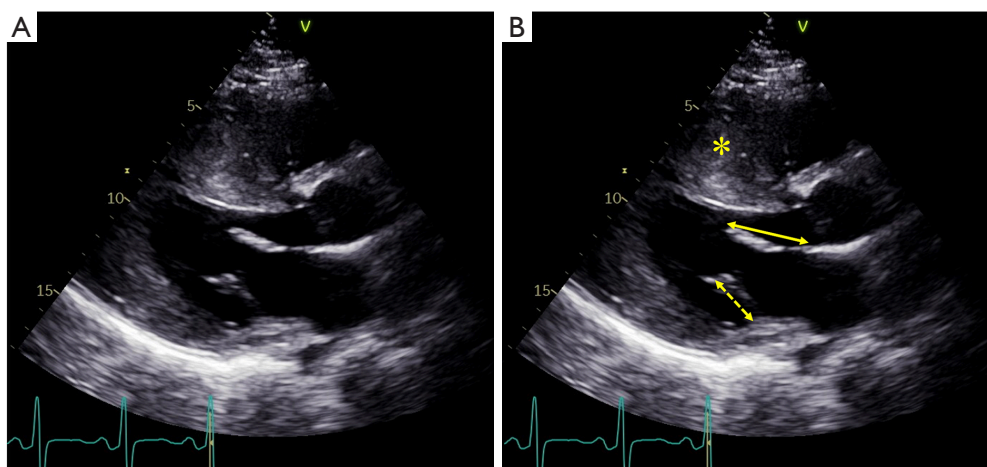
Elongated mitral valve leaflets in hypertrophic cardiomyopathy. (A) A mid-diastolic parasternal long-axis view; (B) the double-headed arrow highlights an elongated anterior mitral leaflet measuring 28 mm, the double-headed dashed arrow highlights an elongated posterior mitral valve leaflet measuring 16 mm, and the asterisk highlights a markedly thickened interventricular septum measuring 30 mm with a reverse curve morphology.
